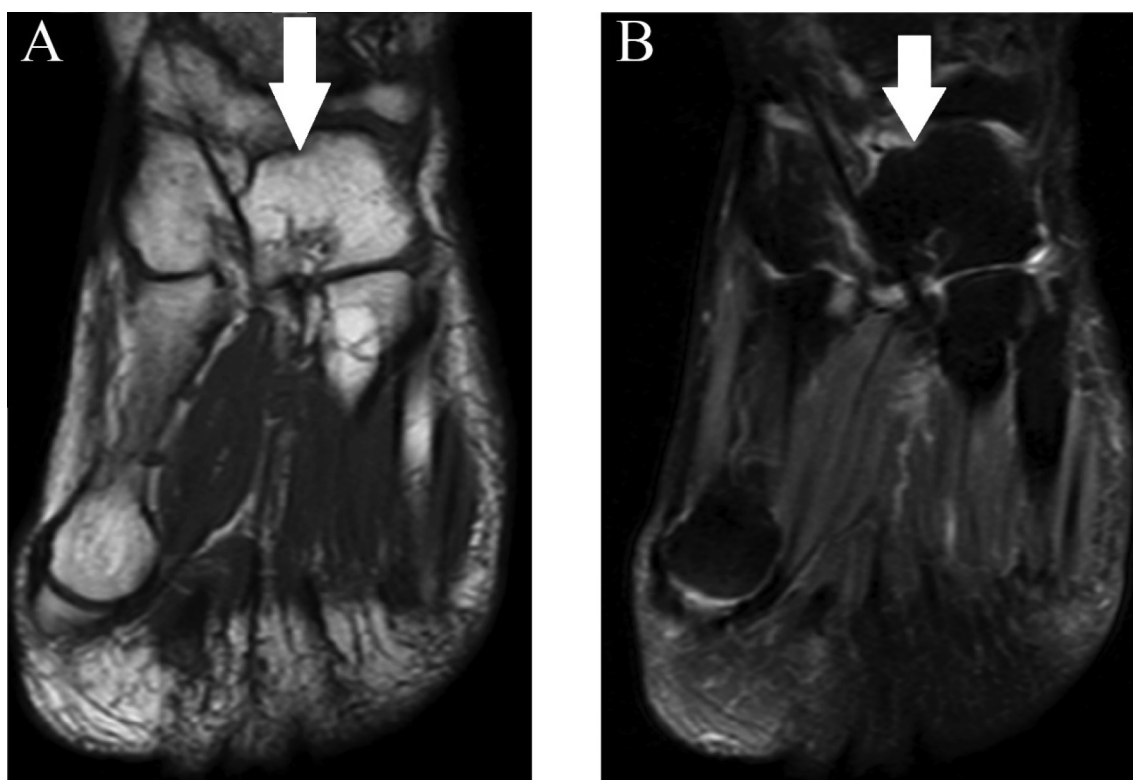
MRI of the left foot in the axial section in the T1 sequence in A and T2 FAT SAT sequence in B demonstrating the lateral-cuboid cuneiform bone coalition (white arrow).
